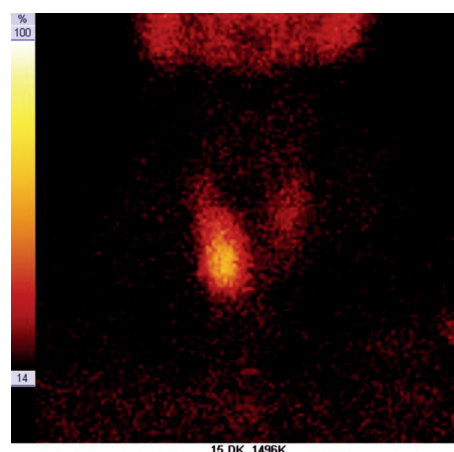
Parathyroid scintigrafi imaging.
